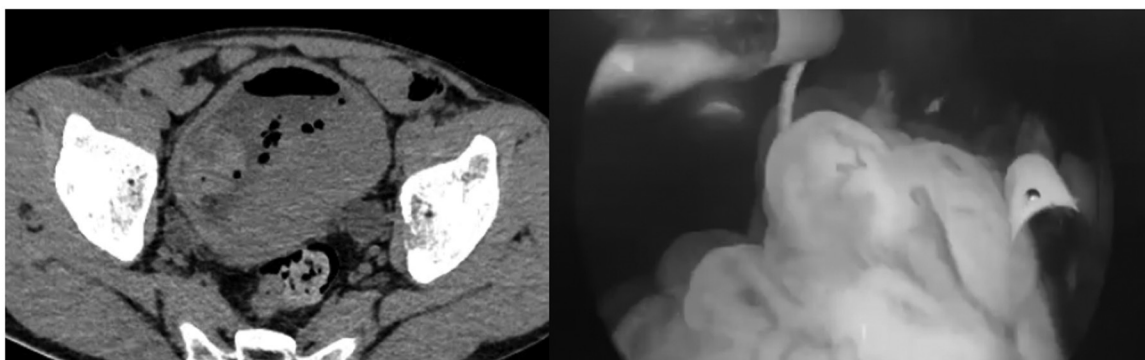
Left: Axial view of the CT scan showing the urinary bladder mass (encircled).
